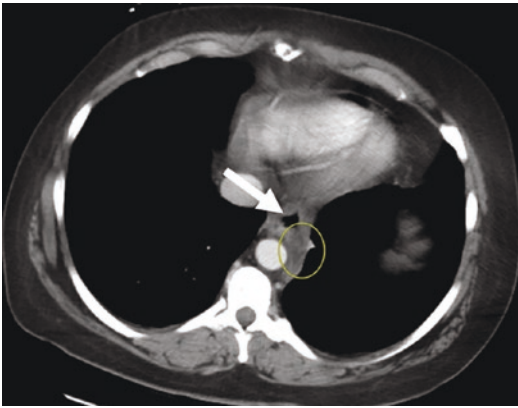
CT scan showing esophagus (white arrow) with a surrounding small fluid collection in the mediastinum (encircled) after a paraesophageal hernia repair. The 3.1×1.4 cm low-density fluid collection is present posterior to the esophagus, without wall enhancement, wall thickening, or gas thus suggestive of a hematoma
